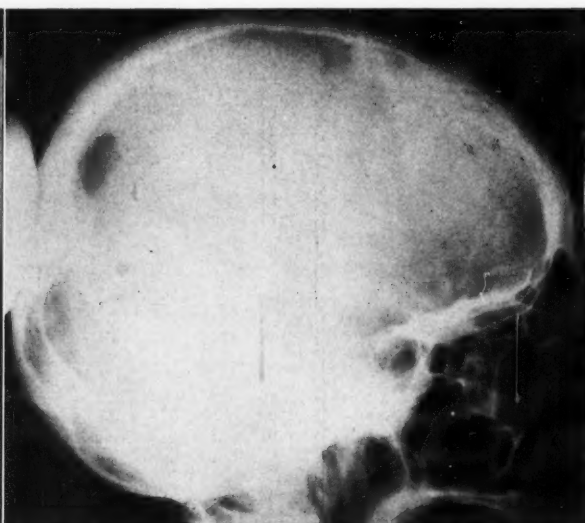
Case II. X-ray of skull with bony defect involving inner and outer table of left parietal bone.
